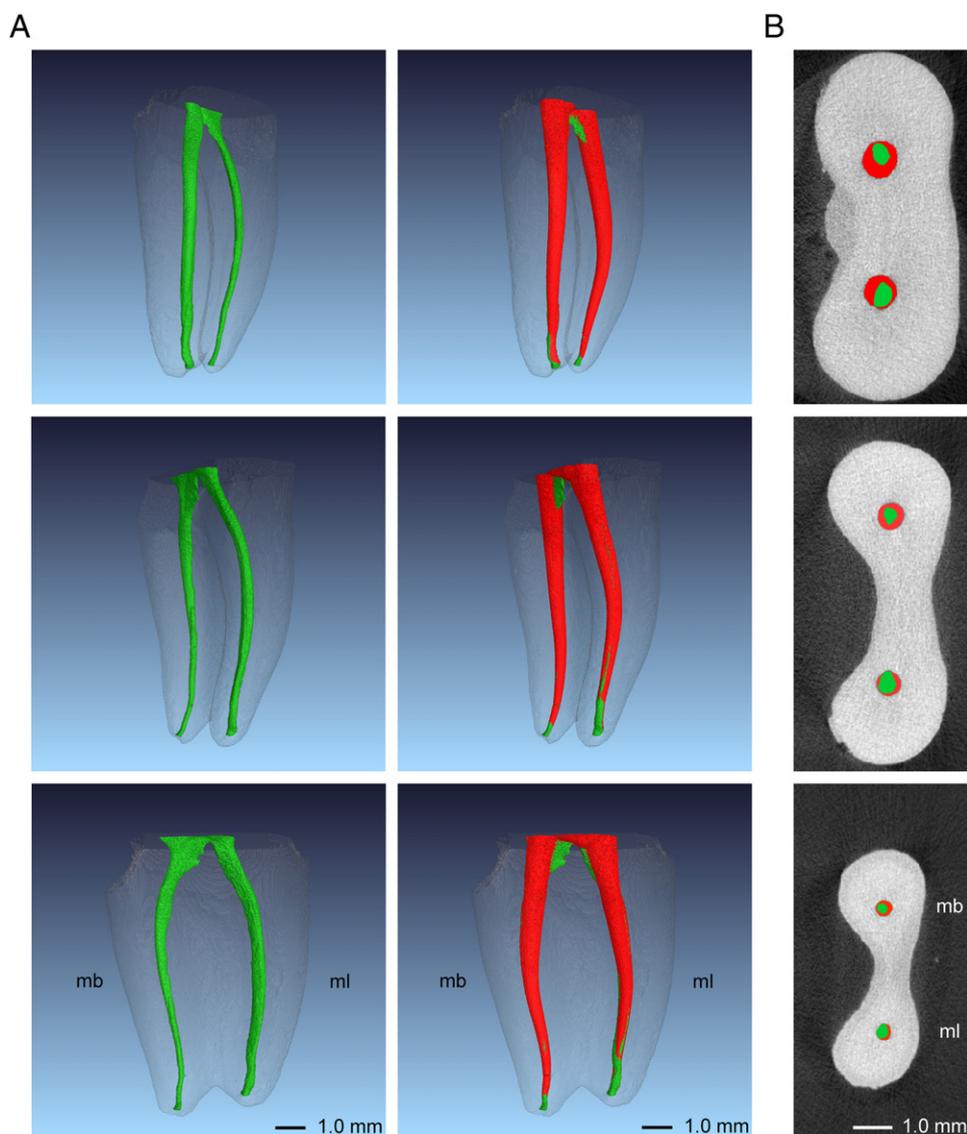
Representative example of μ CT data of mesial canals in mandibular molars, initially (left column) and prepared (middle column) with either reciprocating single-file (mesiobuccal [mb] canal) or rotary full-sequence technique (mesiolingual [ml] canal). (A) Three-dimensional views from the mesial, distal, and mesiodistal in the top, middle, and bottom rows, respectively. Green area is unprepared; red area is prepared. (B) Cross sections in the apical, middle, and coronal root canal thirds. Green and red areas are preoperative and postoperative cross sections, respectively.
